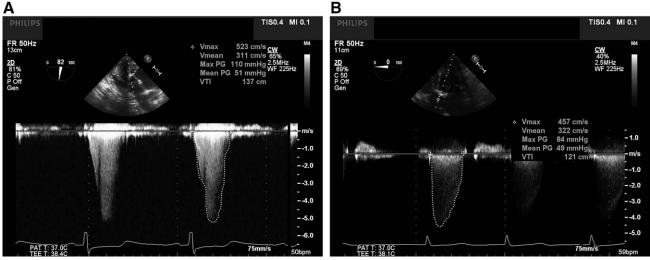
A, Mid- to late-peaking systolic, dagger-shaped profile in a hypertrophic cardiomyopathy patient (continuous wave Doppler; transgastric long-axis (TG-LAX) view, transesophageal echocardiography (TEE) consistent with a subvalvular, dynamic left ventricular outflow obstruction. B, Continuous wave Doppler (CWD) of severe aortic stenosis patient with fixed obstruction. Early systolic peaking parabolic-shaped profile of severe aortic stenosis patient. Deep TG-LAX view. TEE image.
